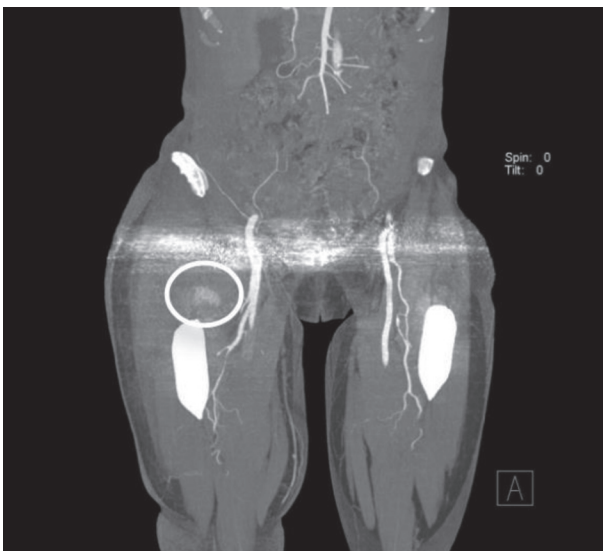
Active arterial bleeding on angio-CT scan
